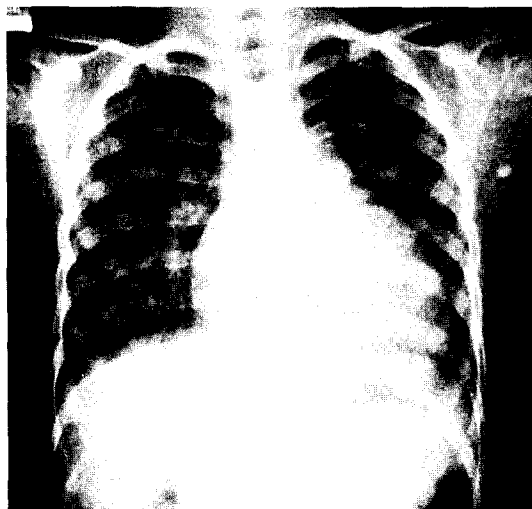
The preoperative chest X-ray revealed some prominent pulmonary vascularity. The overall heart size was normal with slight prominence of the left atrial appendage.
